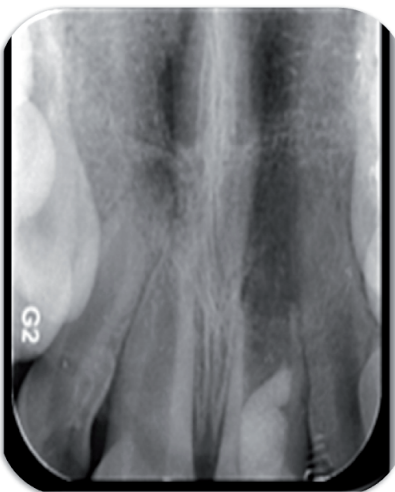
X-ray taken after second session and setting of the PRF and MM-MTA.
